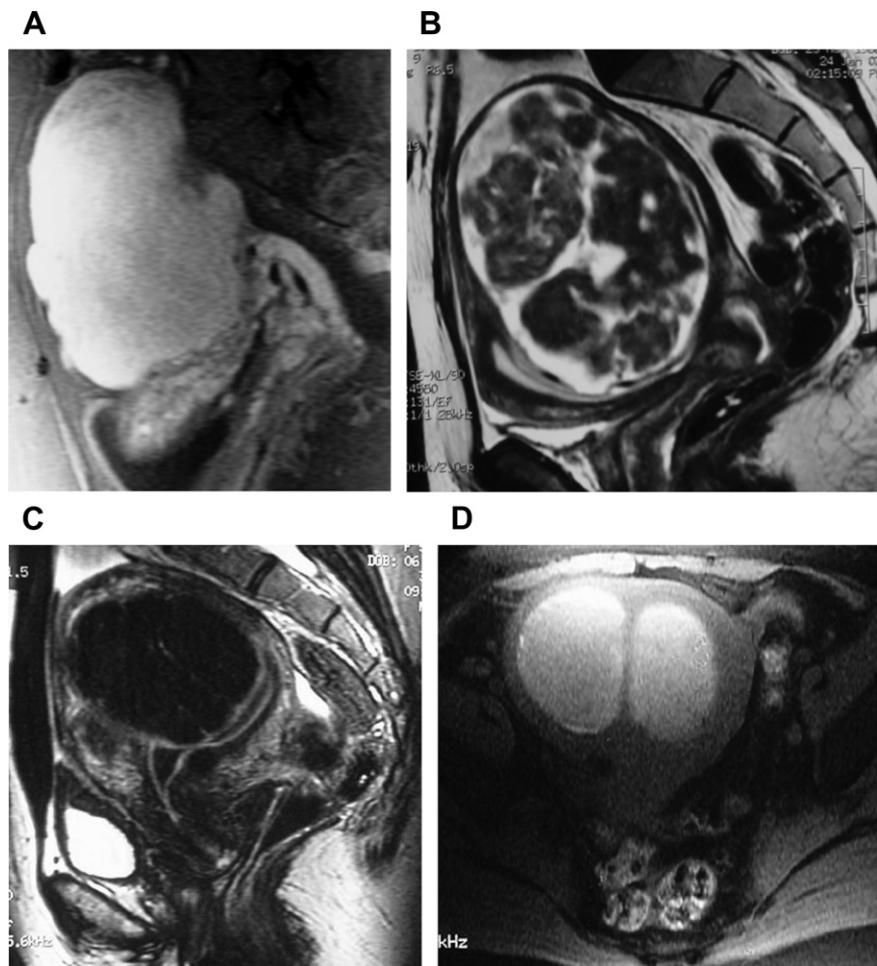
Leiomyomas. (A) Cellular leiomyoma with marked enhancement on contrast-enhanced images. (B) Myxoid degeneration with high SI focus on T2-weighted images. (C) Hyalinized leiomyoma. Well-circumscribed mass, hypointense on T2-weighted images. (D) Red degeneration exhibits diffuse high SI on T1-weighted image.
